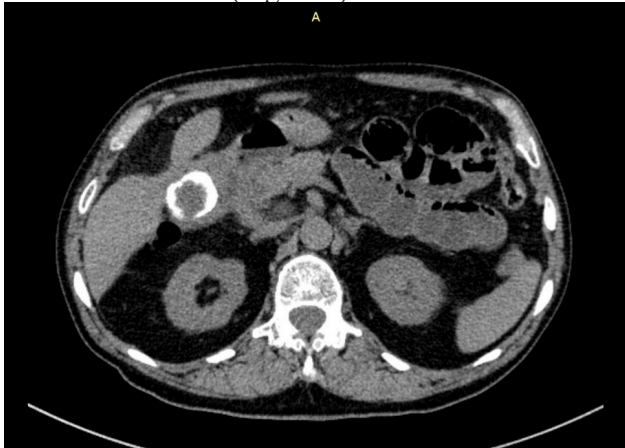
Abdominal CT, highlighting the calculus within the small intestine
